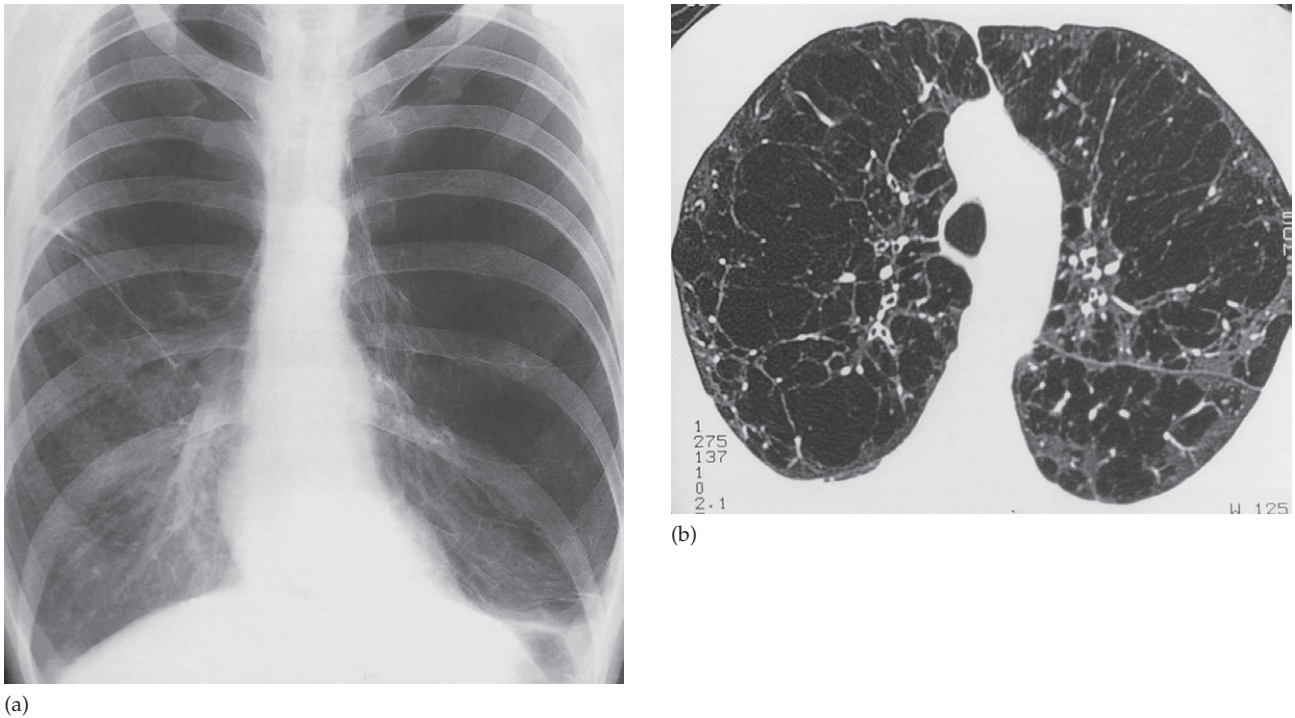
Panacinar emphysema. (a) The diaphragm is low and flat and the ribs are widely spaced, indicating overinflation of the lungs. The peripheral vessels in most of the left lung and the upper half of the right lung are small and attenuated, indicating lung destruction. (b) CT showing innumerable bullae.
